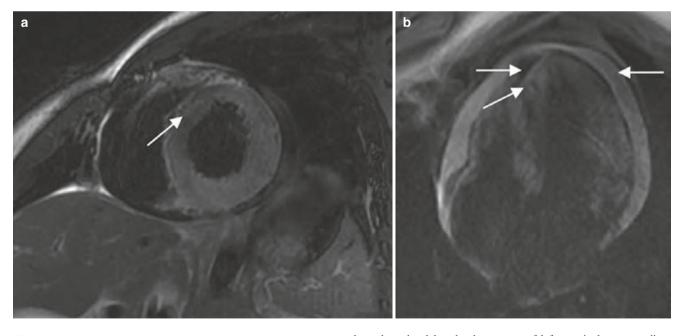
Viral myocarditis. (a) In enhanced MRI scan of heart, T_2WI black-blood technique shows diffuse hyperintensities of left ventricular myocardium (arrow) and (b) late gadolinium enhancement (LGE) T_1WI
